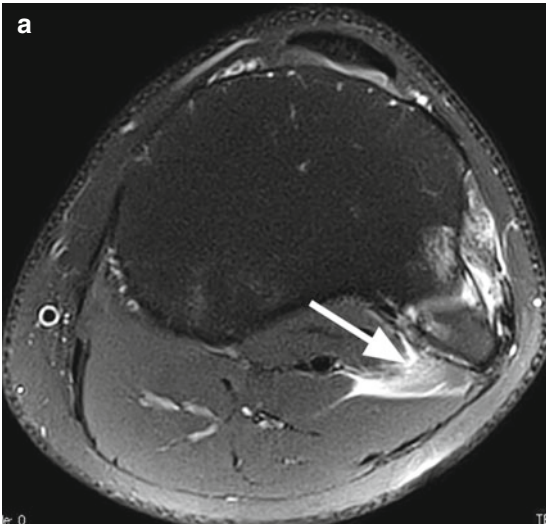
Moderate partial tear of the musculotendinous junction of popliteus muscle in a 26 year old male. Axial proton-density (PD) fat-suppressed image (a), sagittal T2-weighted fat-suppressed image (b), and coronal
